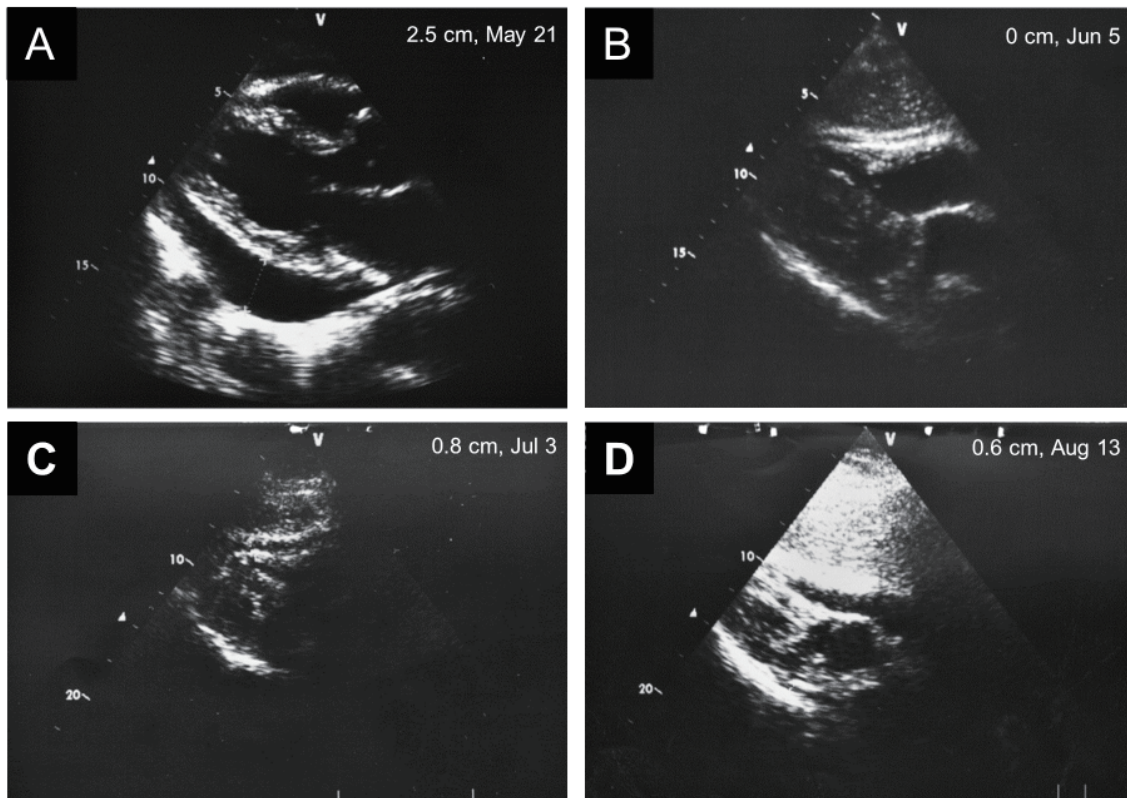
Quantitative assessment of pericardial effusion size in the patient was detected by pericardium B ultrasound, which was usually defined as the maximum diastole dark space in the pericardial cavity. (A) The quantity of pericardial effusion before pericardium puncture (2.5 cm); (B) The quantity of pericardial effusion after drainage (0 cm); (C) The quantity of pericardial effusion after instillation of Cinobufacini injections two weeks later (0.8 cm); (D) The quantity of pericardial effusion after instillation of Cinobufacini injections one month later (0.6 cm).
